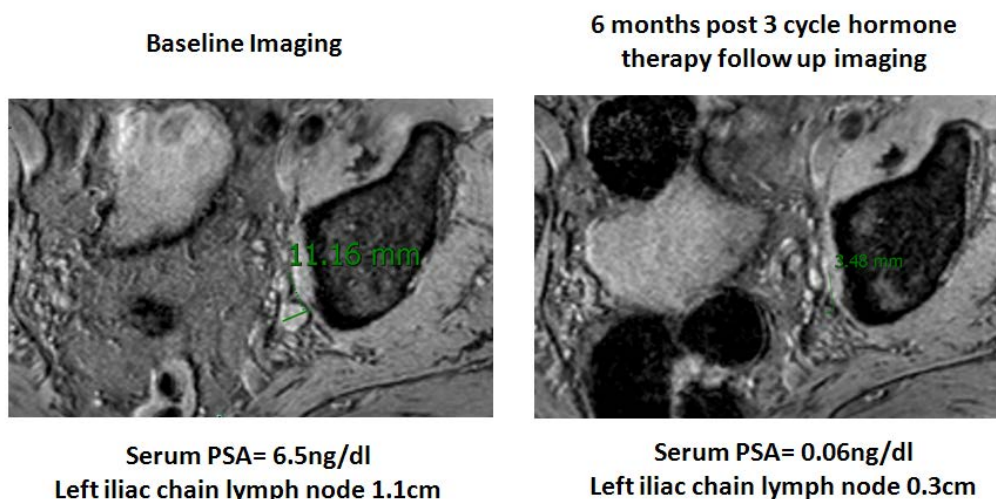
Example of the use of follow up studies. Baseline imaging demonstrates a lymph node with a short axis size of 1.1cm in presence of a serum PSA of 6.5ng/dl in a 72-year old S/P radical prostatectomy patient. 6 months follow up MRI after 3 cycles of hormone therapy demonstrates decrease of the lymph node size to 0.3cm accompanied with a PSA of 0.06ng/dl. The original lymph node would be considered malignant based on its shrinkage on appropriate therapy
